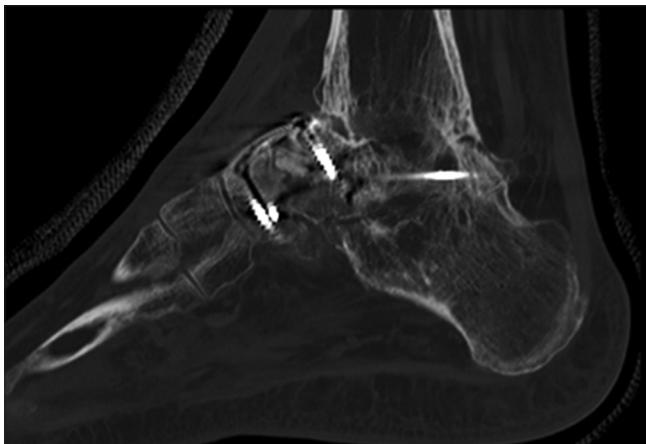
This 6th-month postframe removal computed tomography scan confirmed excellent bony healing with full integration of both fragments as well as healing of the fracture nonunion site
